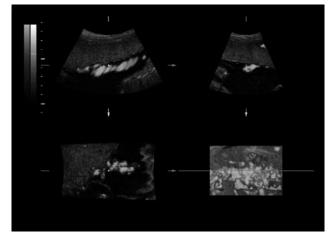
Three-dimensional power Doppler of umbilical cord insertion at the placenta
